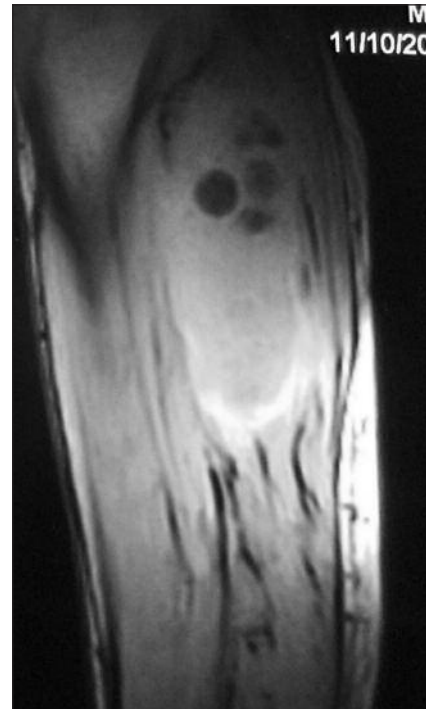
Cysts detected with magnetic resonance imaging, sagittal image.
